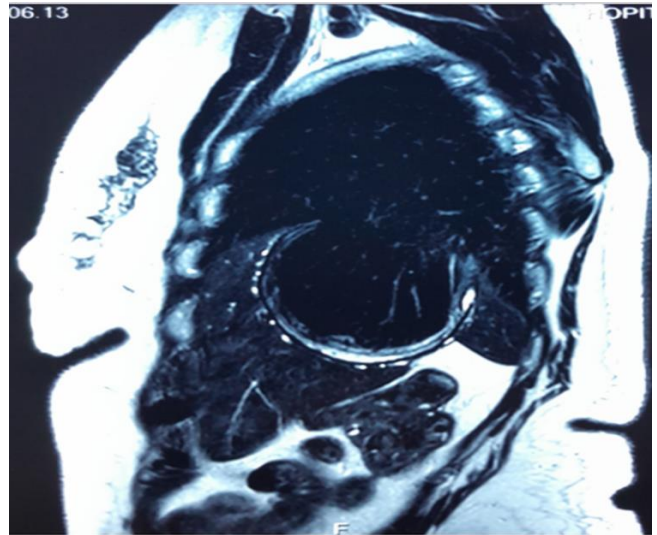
Diaphragmatic MRI examining the integrity of the phrenic membrane and revealing a residual cavity overlapping hepatic segments VII and VIII with calcified shell containing lung parenchyma and small fluid effusion, diaphragmatic defect overlooking the shell extending over 60 mm.
